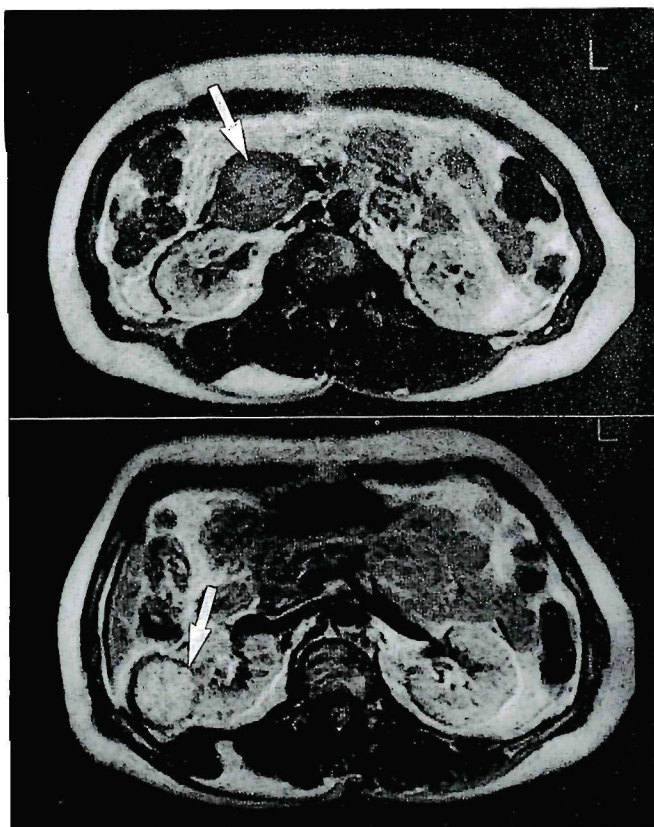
Proton density weighted MRI demonstrating low intensity of pancreatic tumor (top, arrow) compared with high intensity of renal cell carcinoma (bottom, arrow).
